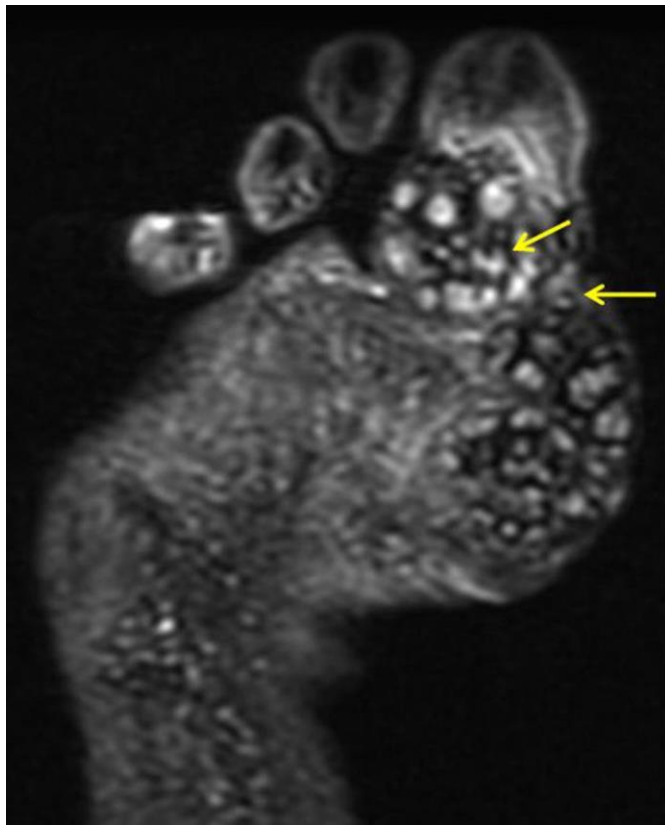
dot-in-circle appearance in Sagittal T2-weighted MRI image.
